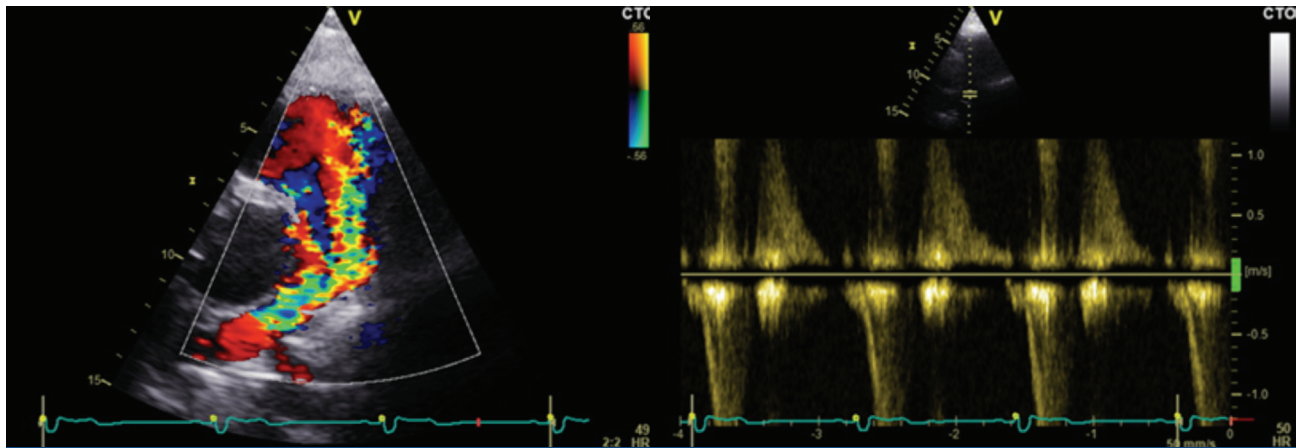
Color Doppler and pulsed wave Doppler with the sample volume in the pulmonary artery showing reversed flow in the pulmonary artery during diastole.
